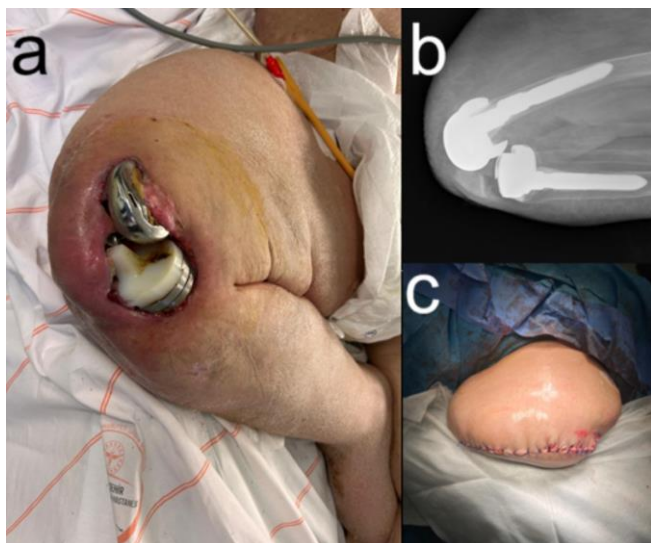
a) Appearance of joint arthroplasty exposed by infection-related skin necrosis on the patient's knee. b) Radiographic image of the same patient's knee. c) Appearance of the extremity after transfemoral amputation.
